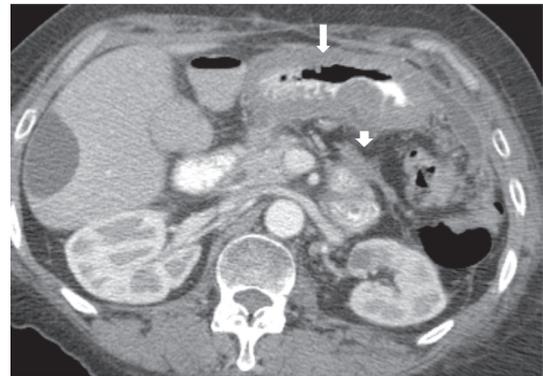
53-Year-old female with diffuse-subtype gastric carcinoma. Axial postcontrast CT image demonstrating circumferential involvement of the gastric body (arrow), with gastrosplenic carcinomatosis (arrowhead), and ascites scalloping around the liver.
